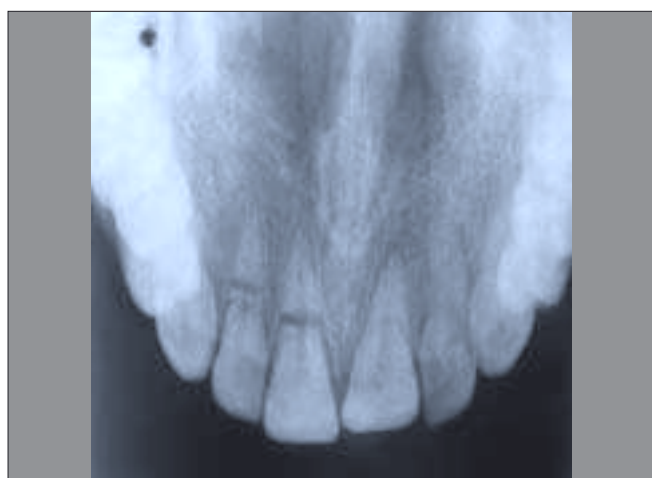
Preoperative occlusal radiograph showing horizontal root fractures of upper right central and lateral incisors
